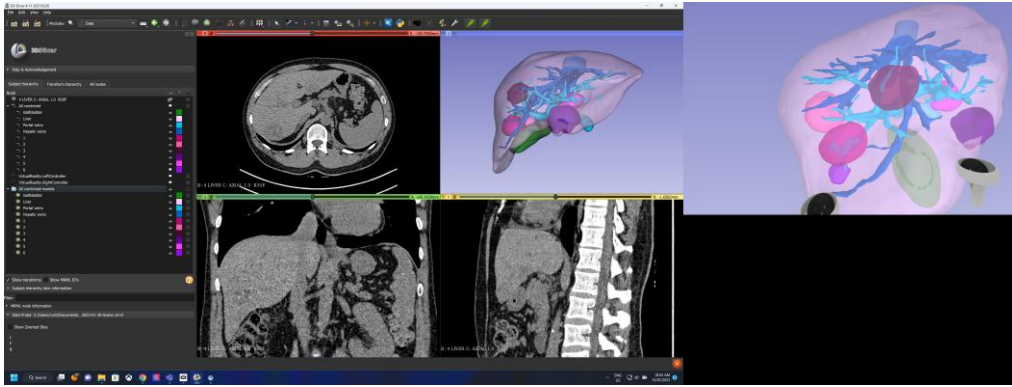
Virtual reality demonstration of the 3D models for the multifocal hepatocellular carcinoma case using the SlicerVirtualReality extension for 3D Slicer and the Meta Quest 2 headset and controllers. Left: the observation panel in 3D Slicer displaying the non-contrast CT in the axial (red), coronal (green) and sagittal (yellow) planes, and the 3D render of the models (purple). Right: the VR view from SteamVR during the demonstration.
